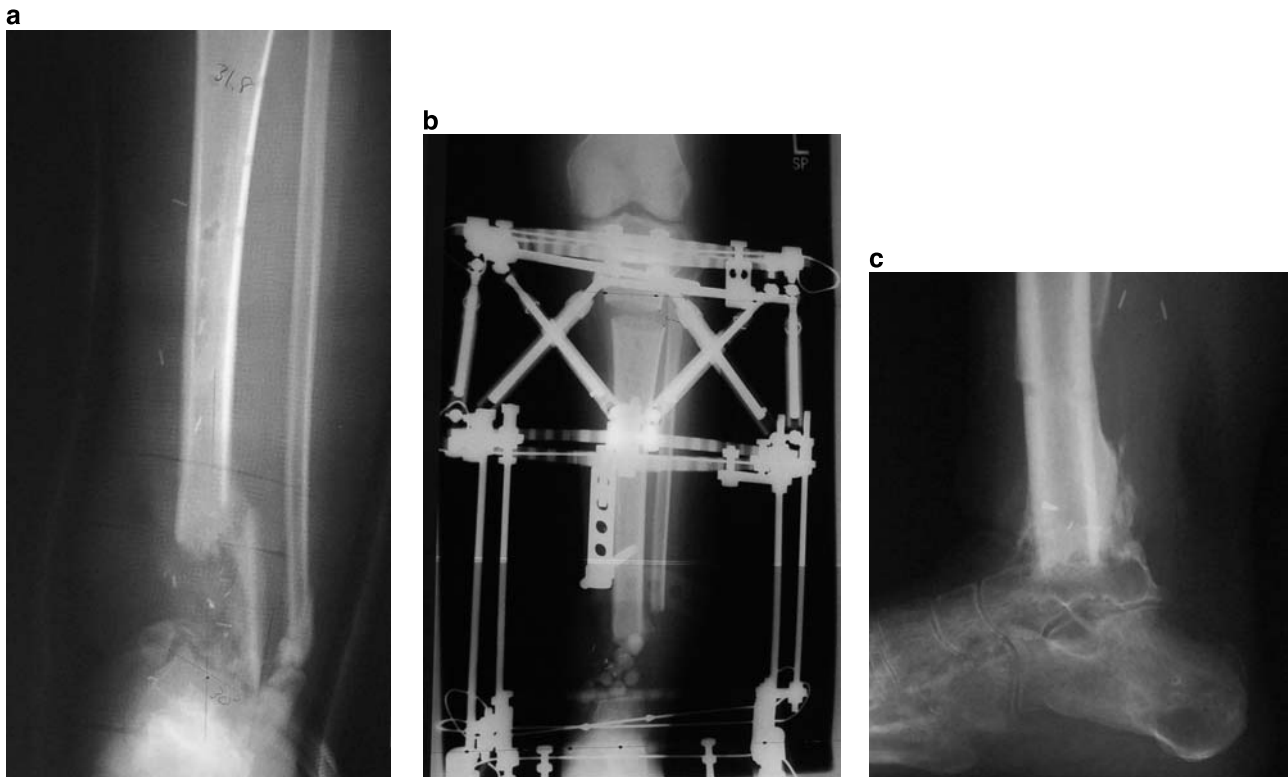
a AP radiograph showing an infected nonunion bone defect of the distal tibia and articular surface. b AP radiograph showing a 2-level frame for proximal tibia lengthening and gradual shortening of the defect and ankle fusion. c Lateral x-ray showing a successful ankle fusion. A 10-cm proximal tibia lengthening was performed on this patient
